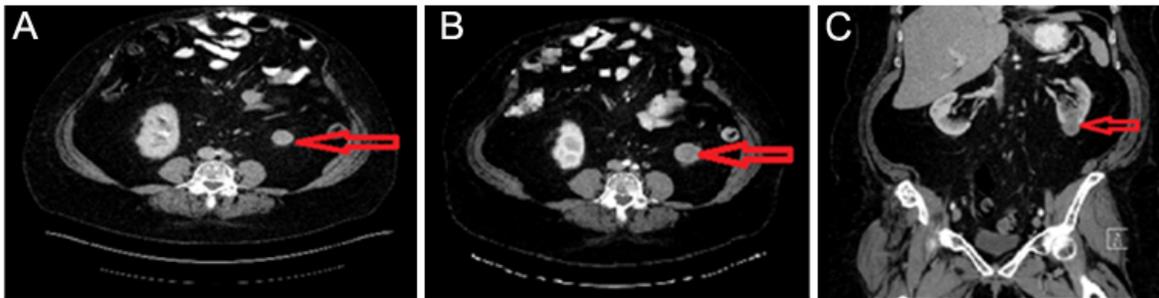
CT scan performed revealed an enhancing mass (red arrows) measuring 2.4 cm × 2.8 cm arising from lower pole of the left kidney. B. CT scan performed 17 months later reveals an increase in size of the mass (red arrows) which now measures 3.4 cm × 3 cm. C. Coronal CT which shows the mass (red arrows). The differential diagnosis of this mass based on imaging was a renal cell carcinoma or a LMS involving the left kidney (due to previous history)
